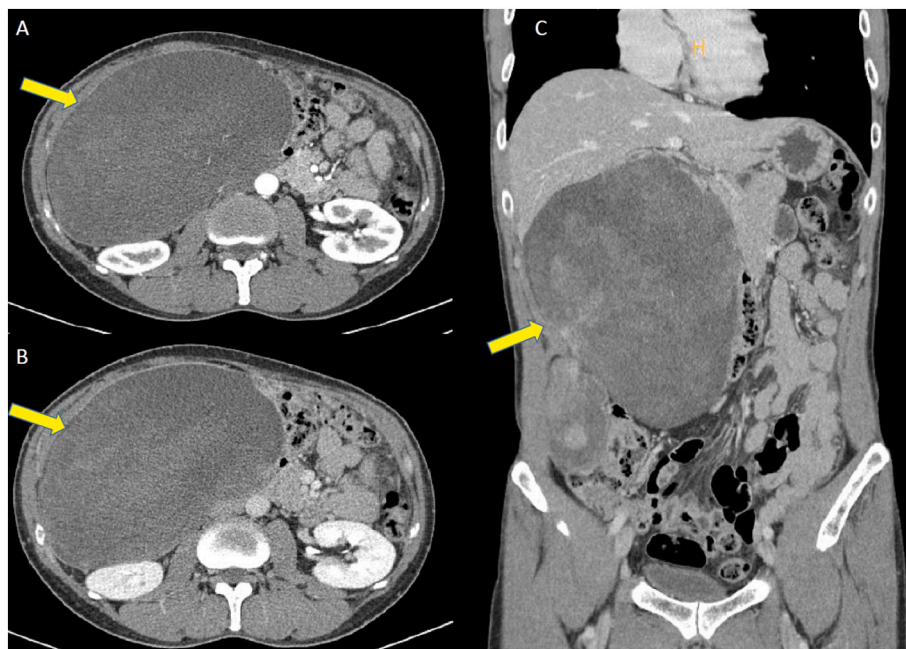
Abdominal pelvic CT scan – About 25.5 × 19 cm sized mass at right abdomen with encapsulation, A) sagittal view, arterial phase, B) sagittal view, portal phase, C) Coronal view.
